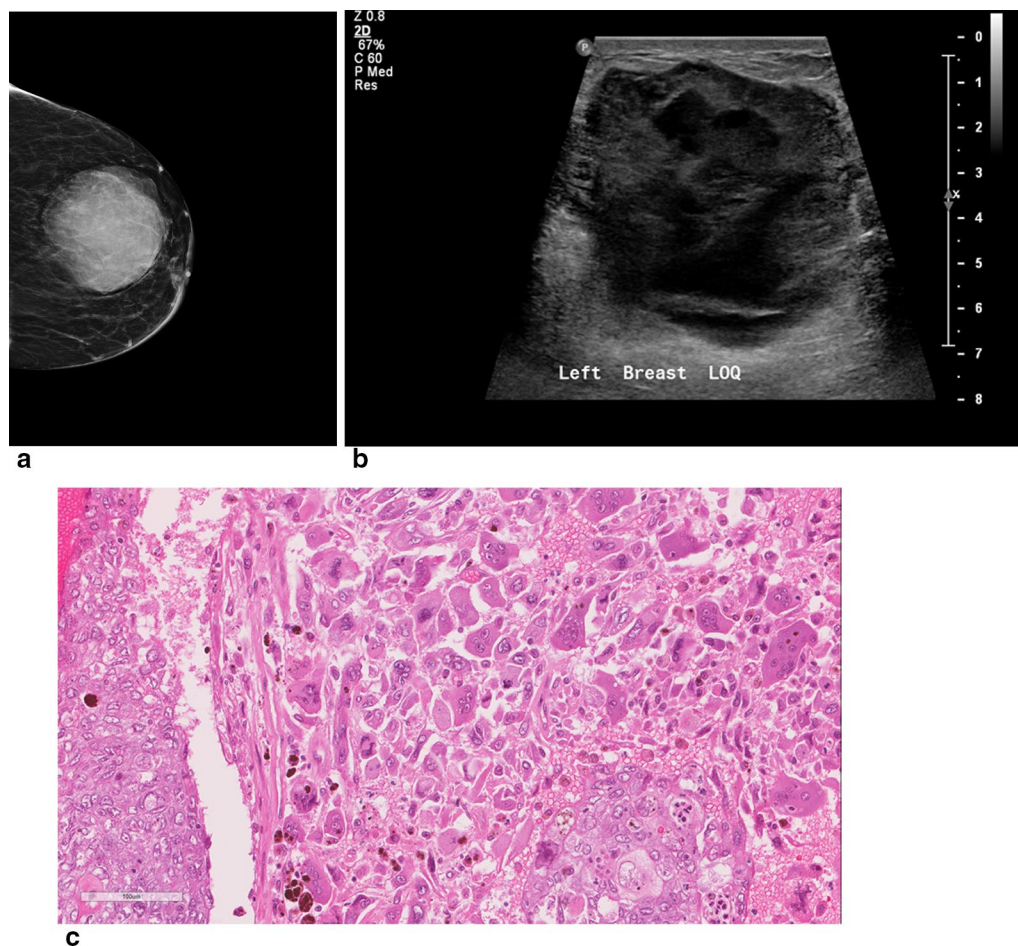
A large left breast mass in an 82-year-old woman with mesenchymal differentiation subtype. a The craniocaudal view of mammogram shows a rounded, dense mass with circumscribed margins and mild periareolar skin thickening. b The ultrasound shows an irregular shaped mass with indistinct margins along with complex echotexture and posterior enhancement. c The pathology shows a metaplastic carcinoma with mesenchymal differentiation showing prominent multinucleated giant cells
